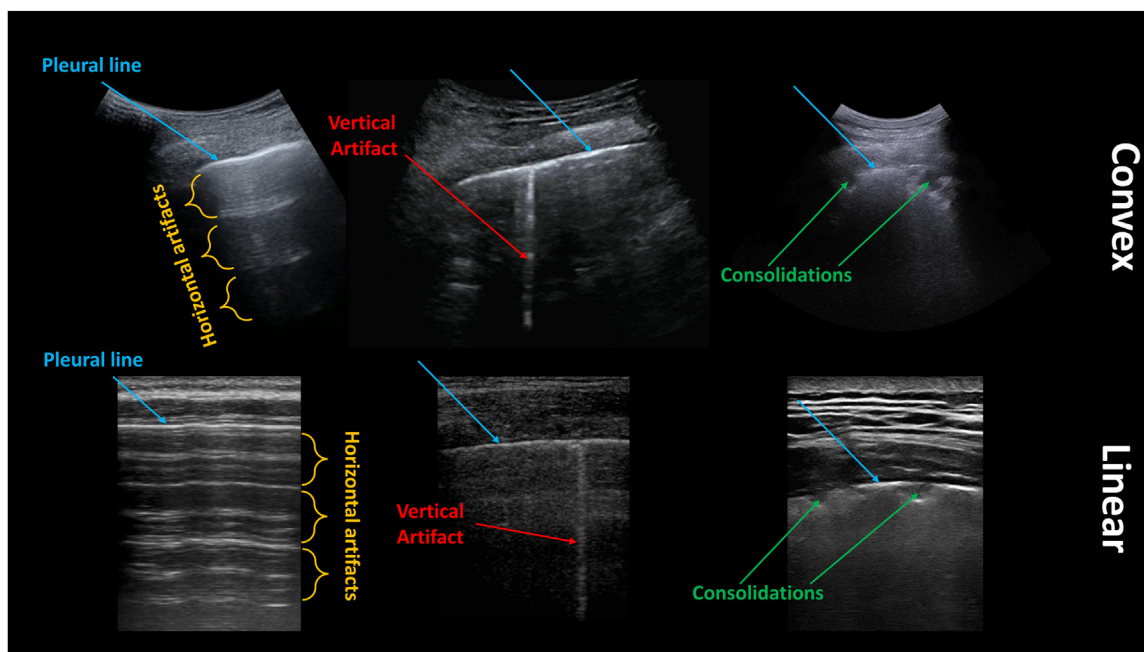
Examples of lung ultrasound images acquired with convex (top) and linear (bottom) probes. Pleural lines, horizontal artifacts, vertical artifacts and consolidations are indicated in blue, orange, red, and green, respectively.
